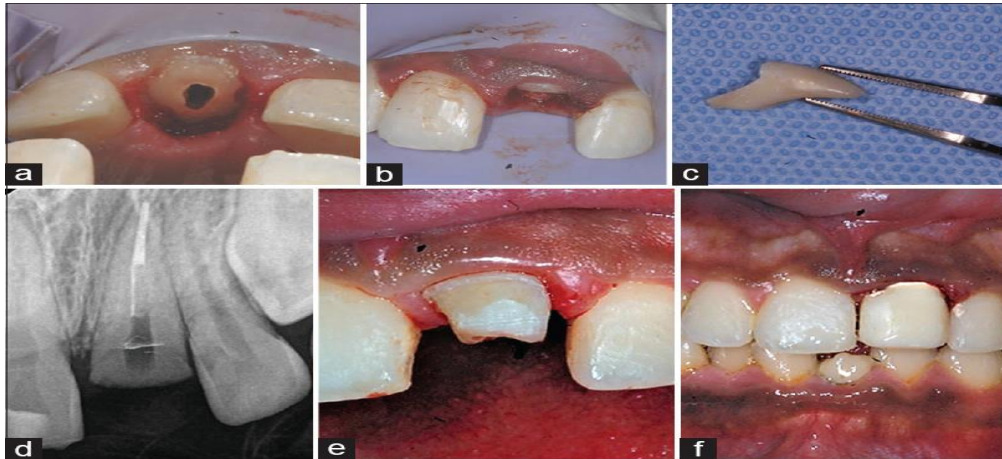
Clinical photos after removal of the broken coronal segment (a-c). Periapical radiograph after root canal treatment and postspace preparation (d). Clinical photo of core buildup (e). Clinical view after cemented temporary crown (f) (Bourguignon, *et al.*, 2020).
